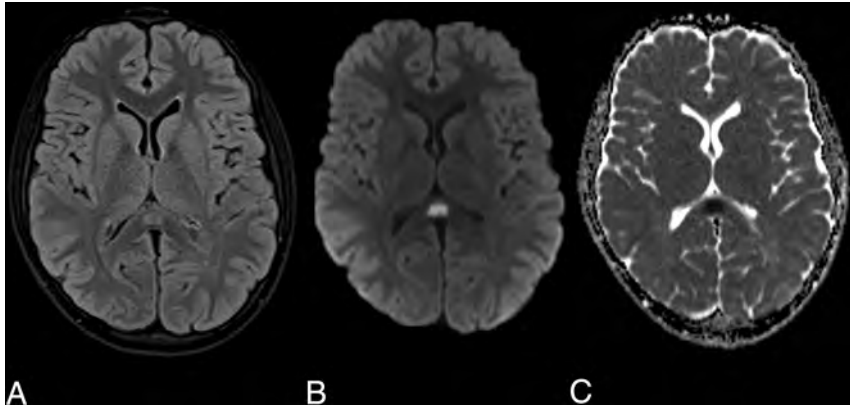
Axial MR images demonstrate an oval T2-weighted hyperintensity in the splenium of the corpus callosum (A) with associated restricted diffusion on the DWI (B) and ADC maps (C).
